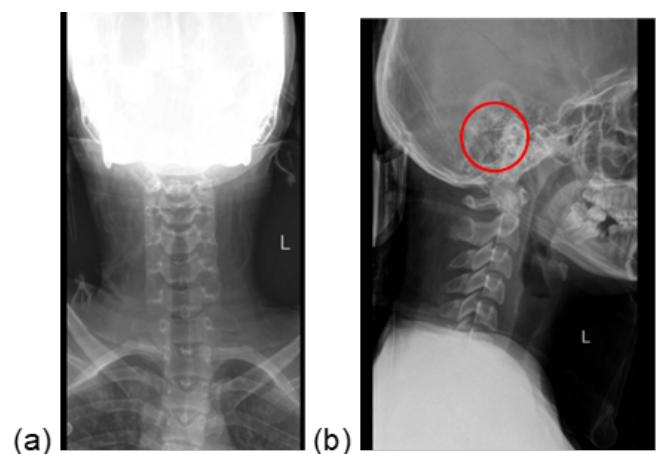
(a). Anteroposterior cervical radiograph demonstrating the craniocervical junction without apparent malalignment (b). Lateral cervical radiograph showing a suspected left occipital condyle fracture (circled), characterized by cortical irregularity at the craniocervical junction, radiographically consistent with an Anderson–Montesano type II and Tuli type I occipital condyle fracture.
